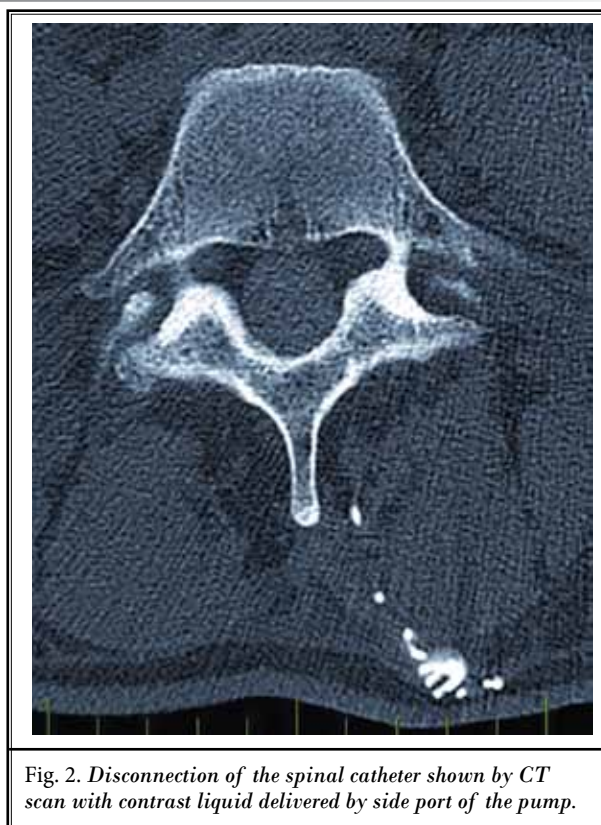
Disconnection of the spinal catheter shown by CT scan with contrast liquid delivered by side port of the pump.
